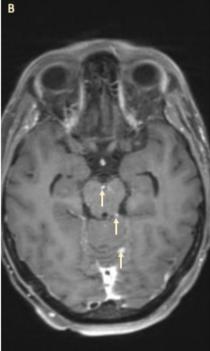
Intracranial and Spinal Appearance of Leptomeningeal Disease. A MRI brain with contrast demonstrating multiple leptomeningeal deposits (arrows). B MRI brain with contrast demonstrating leptomeningeal deposits involving the brainstem and cerebellum
